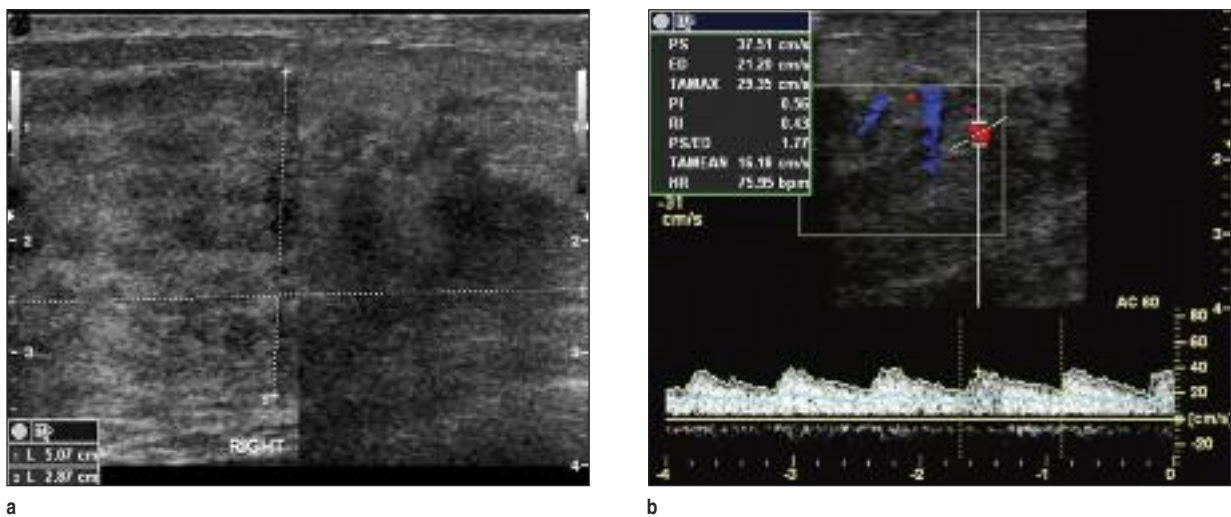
US examination of the same patient in Figure 1, IGM of the right breast is seen as large heterogeneous hypoechoicity containing internal hypoechoic tubular lesions giving no posterior enhancement or shadowing with indistinct borders. 6b: On Doppler US examination spectral analysis of arterial sampling reveals low resistance arterial flow with peak systolic velocity 37.51cm/s, end diastolic velocity 21.2cm/s,RI:0.43,PI:0.56.
